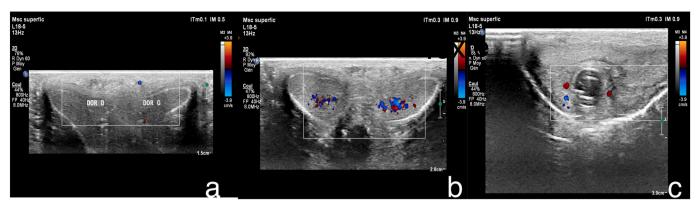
Doppler ultrasound of the penile arteries showing an isolated obstruction of the dorsal right penile artery.
